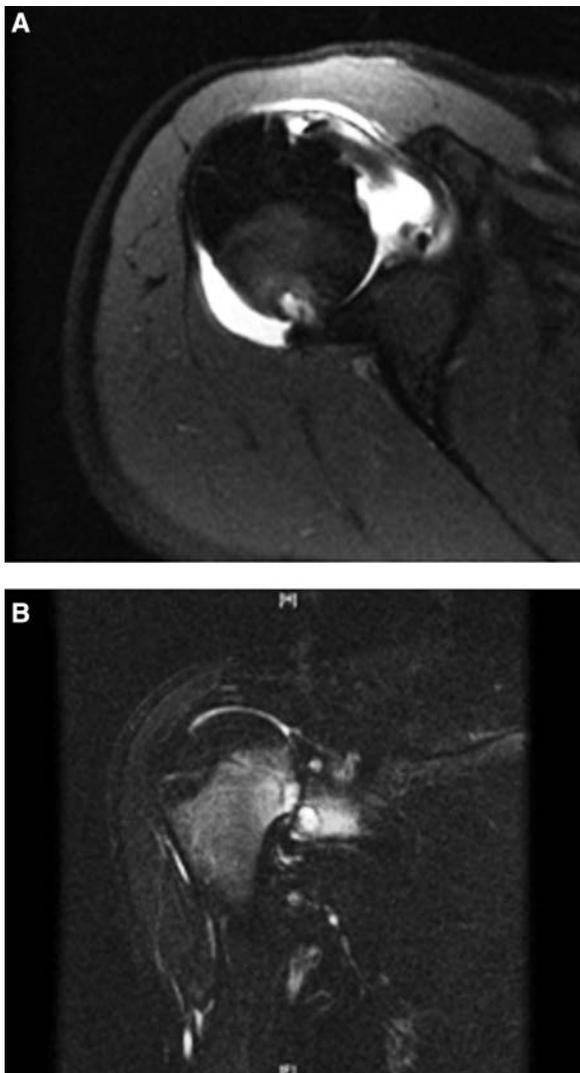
A, axial MRI image of a 22-year-old woman demonstrating full-thickness cartilage loss and a subchondral cyst at the posterior aspect of the humeral head; B, coronal oblique MRI image of the same patient, with cyst formation visible at the glenoid and humeral head. Underlying bony edema is also apparent.
